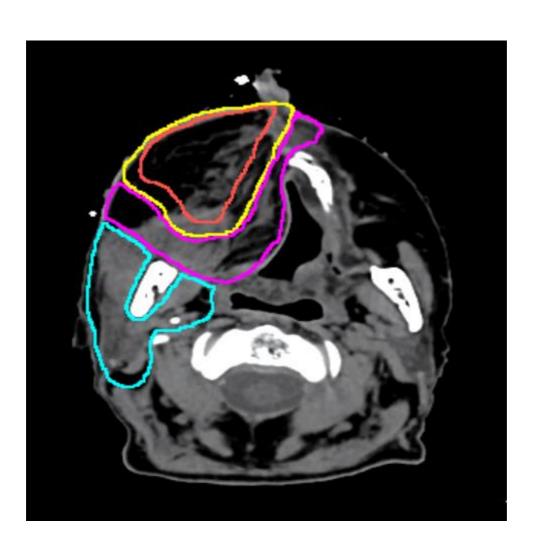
Post-operative target volumes and sagittal post-operative planning CT
